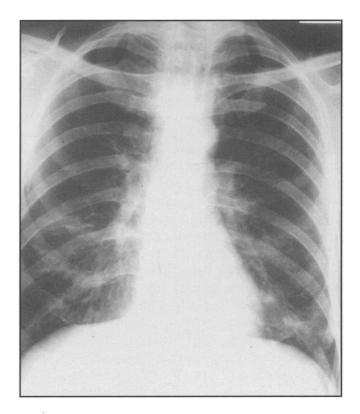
Chest radiograph showing resolution of the previous areas of consolidation but new consolidation at the left base and right mid zone.
